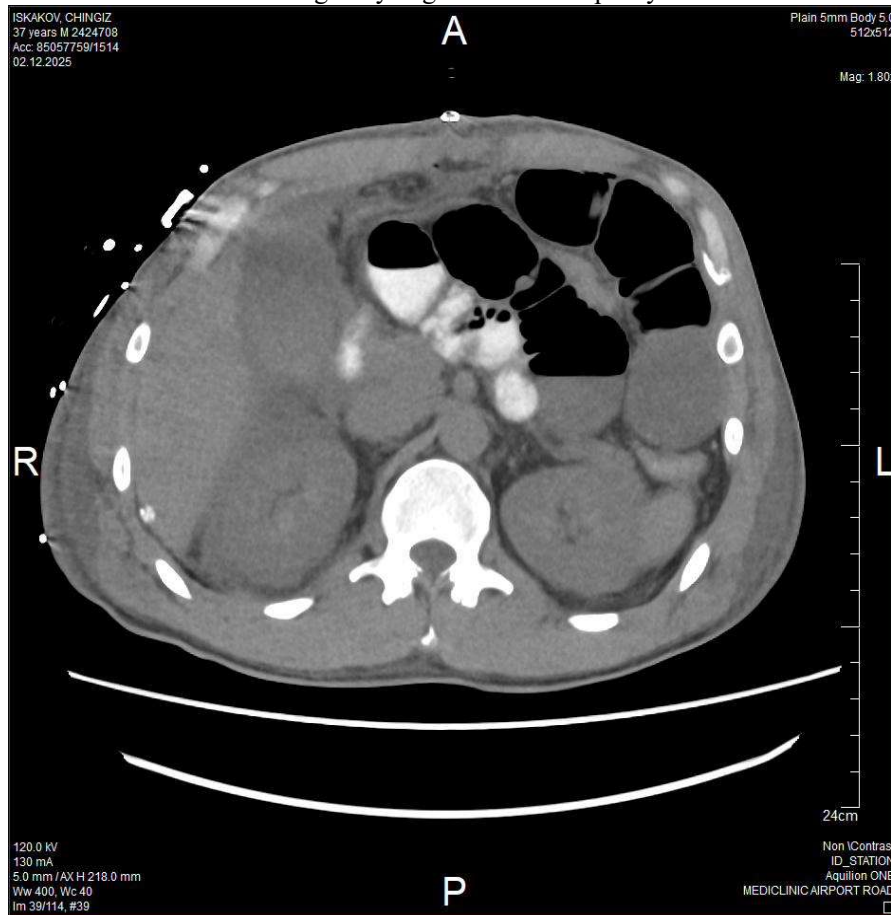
Axial unenhanced CT (Mediclinic Airport Road Hospital, 2 December 2025), three days after diagnostic laparoscopy converted to open laparotomy with duodenal repair and three-drain abdominal lavage. Multiple dilated bowel loops with air–fluid levels reflect post-operative paralytic ileus; the previously noted retroperitoneal collection has substantially regressed.
